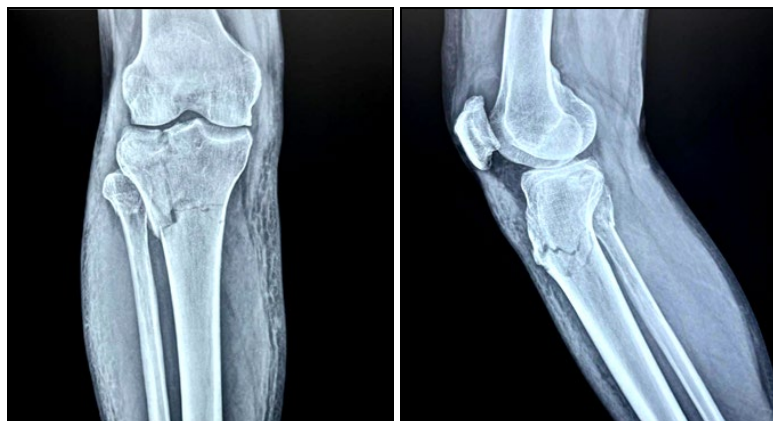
(a): Pre-operative radiograph-AP & Lateral
